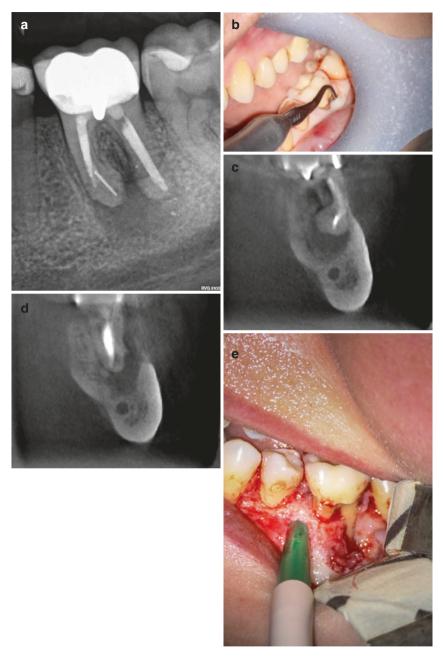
(a) Preoperative radiograph of a mandibular first molar with a fragment at the apical third of the mesial root. The RCT was performed, according to the patient, 12 years earlier. (b) Periodontal involvement. (c, d) A CBCT image revealed the proximity of the periapical lesion to the mandibular canal. (e) Reflection of full mucoperiosteal flap. (f–h) Exposure of the fragment by use of an ultrasonic tip (JeTip 1B, B&L Biotech, USA). (i, j) Removal of the fragment. (k, l) Retrofilling with MTA. (m, n) Graft and membrane placement. (o) Immediate postoperative radiograph. (p) The 36-month recall radiograph revealed uneventful healing (Courtesy of Dr. S. Floratos)
